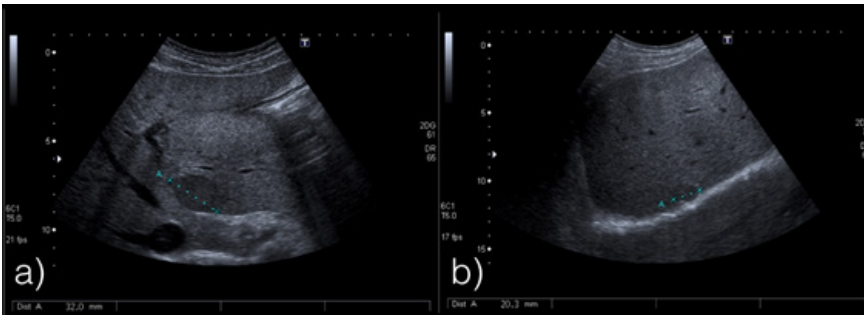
Abdominal ultrasound shows two solid, hypoechoic liver nodules: nodule one (a) - measuring about 3 cm in the subcapsular region of segment 2; nodule two (b) - measuring 2 cm in segment 7.
